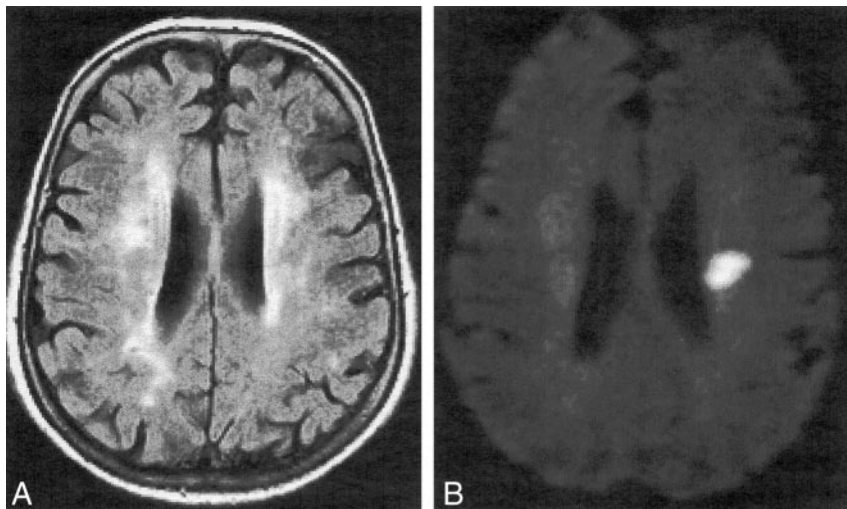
Axial MR images obtained in a 75-year-old man with transient left hemiparesis.
